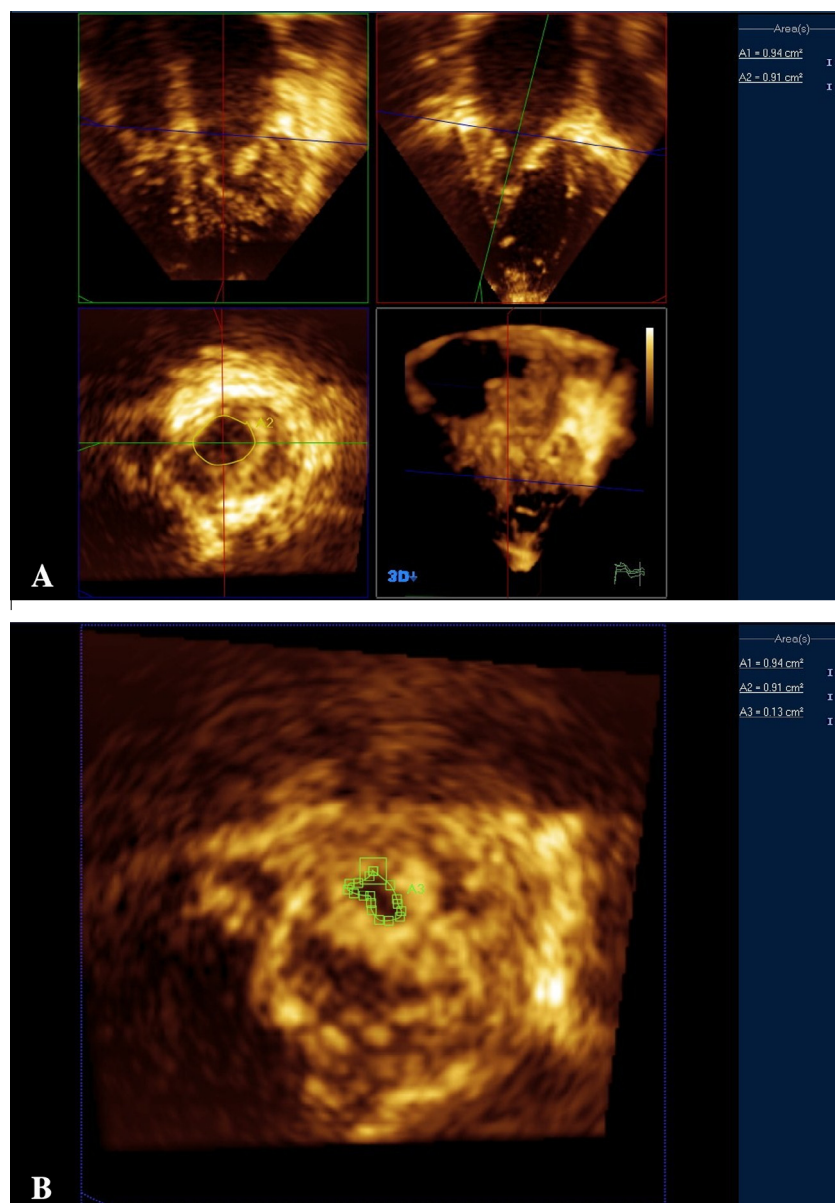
(A) Multiplanar reformatting (MPR) technique used to grade Mitral valve stenosis (MVS) severity demonstrating three colour-coded boxes with 4th box in the right lower quadrant showing full volume three-dimensional echocardiography (3DE) dataset. (B) Blue box in the left lower quadrant is enlarged to calculate the severity of MVS by planimetric determination of mitral valve area (MVA) and it was graded as severe MVS.
